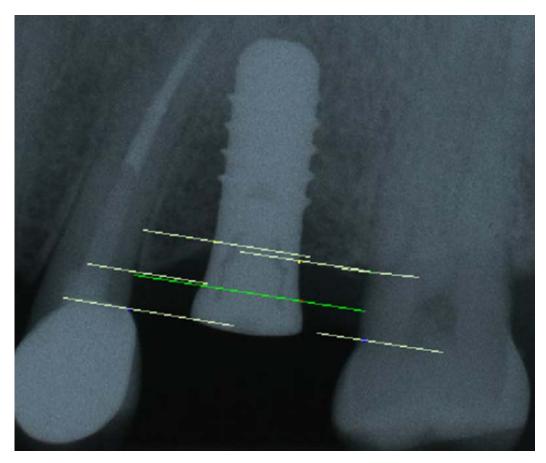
Lines connecting radiographic reference points, drawn parallel to implant prosthetic platform (Green line – Tissue Level implant) for measurements.
